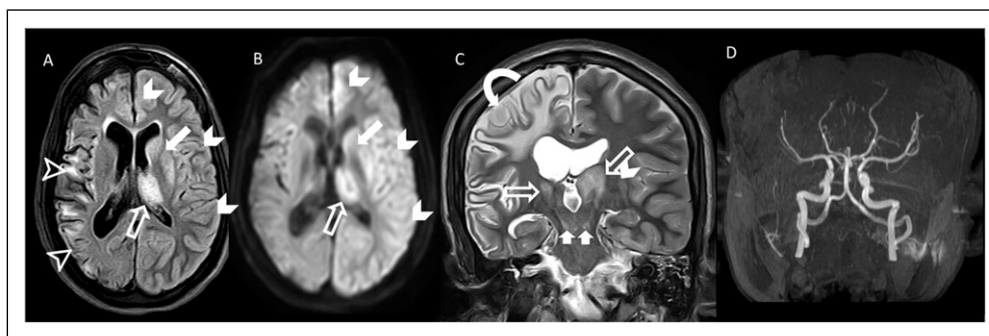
35-year-old woman presented with acute behavioral changes, disorientation, aphasia, hallucinations, and cognitive decline. A. Axial T2-FLAIR-weighted image shows hyperintensity in the left thalamus (open arrow) and basal ganglia (solid arrow). Right hemisphere volume loss with juxtacortical areas of gliosis due to a previous stroke-like event is present (open arrowheads). The left hemisphere cortex (solid arrowheads) is slightly bright and thick in T2-FLAIR-weighted and in DWI images (B) with out restriction. C. Coronal T2-weighted image shows hyperintensity in thalami (open arrows), thalamic tracts (short arrows), and right hemispheric volume loss and gliosis (curved arrow). D. Unremarkable time of flight sequence.
